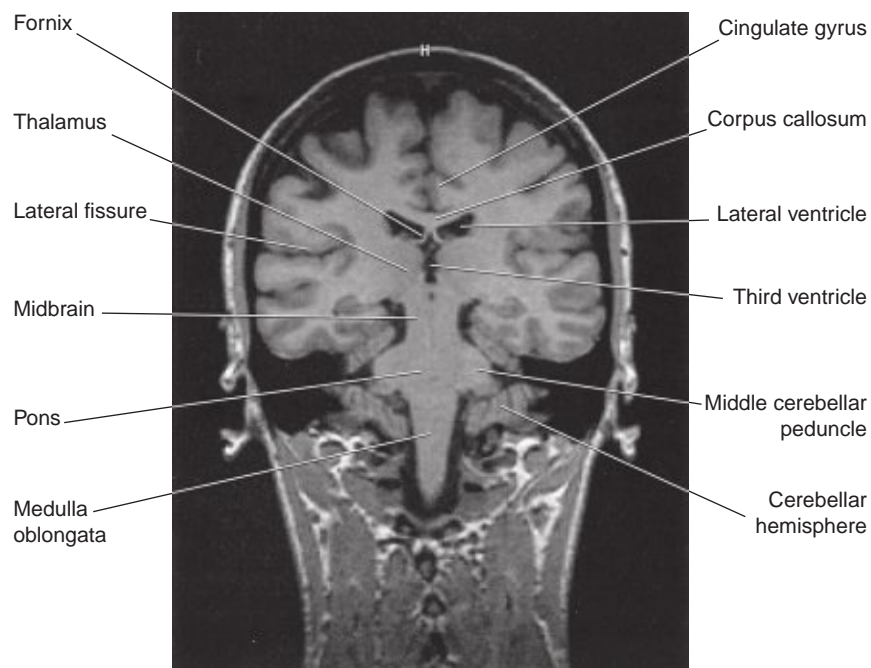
Coronal MRI 'slice' at the level of Figure 2.16. (From a series kindly provided by Professor J. Paul Finn, Director, Magnetic Resonance Research, Department of Radiology, David Geffen School of Medicine at UCLA, California, USA).
